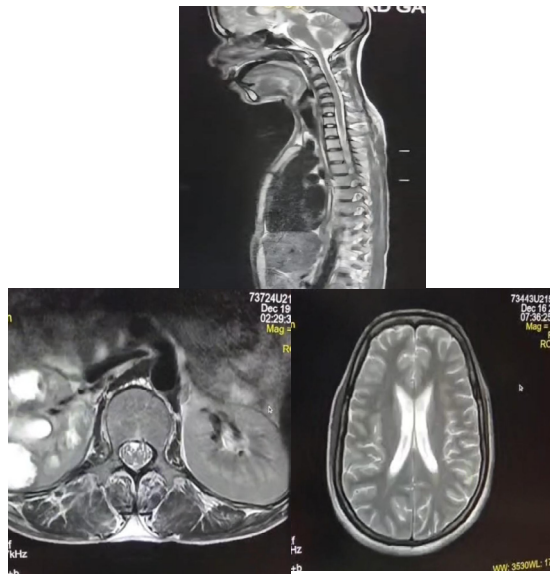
MRI brain and spine at the time of presentation showed no identifiable pathology
